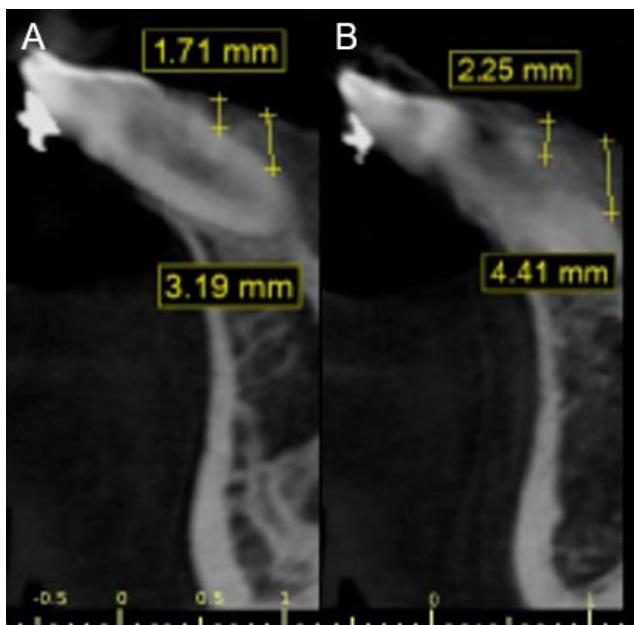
CBCT image axial view. It can be observed the bone regeneration process 1 month (A) and 6 months (B), gaining 2 mm approximately of the lingual bone.
